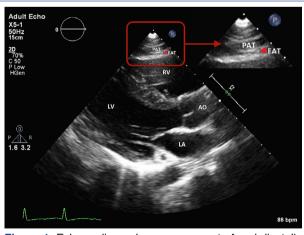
Echocardiography measurement of end-diastolic epicardial adipose tissue thickness from the parasternal long-axis. Ao: Aorta; EAT: Epicardial adipose tissue (arrow-head); LA: Left atrium; LV: Left ventricle; PAT: Pericardial adipose tissue; RV: Right ventricle.
